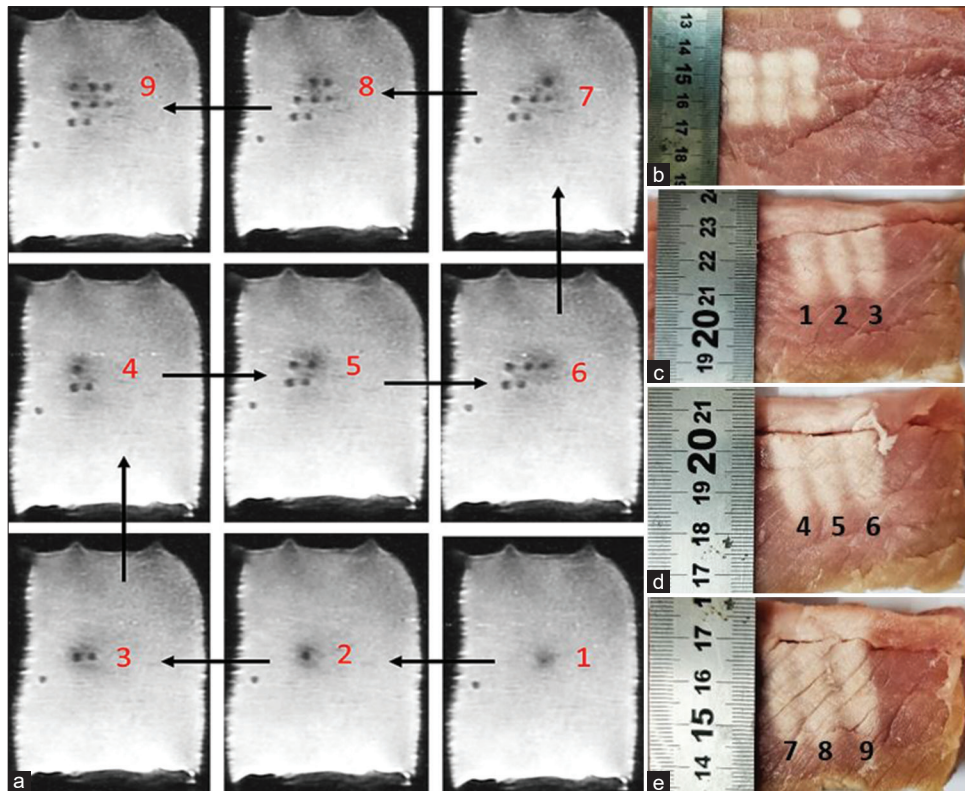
(a) 2D coronal T2-weighted fast spin echo images (repetition time = 2000 ms, echo time = 59 ms, flip angle = 90° , echo train length = 60, pixel bandwidth = 27.10 Hertz/pixel, matrix size = 224×192 , field of view = $260 \text{ mm} \times 260 \text{ mm} \times 6 \text{ mm}$, and number of averages = 2) acquired during ablation in a 3×3 pattern (acoustical power of 54 W for 120, 10-mm step, 60-s delay) in the 1.5 T magnetic resonance imaging scanner. (b) The meat sliced (horizontally) at 10 mm from the sonicated side showing the formed lesions and the reference point lesion. (c-e) Photos of the tissue sliced vertically to assess the extent of necrosis in a plane parallel to the ultrasonic beam propagation: Lesions 1–3 had a length of 29 mm, lesions 4–6 a length of 30 mm, and lesions 7–9 a length of 32 mm
